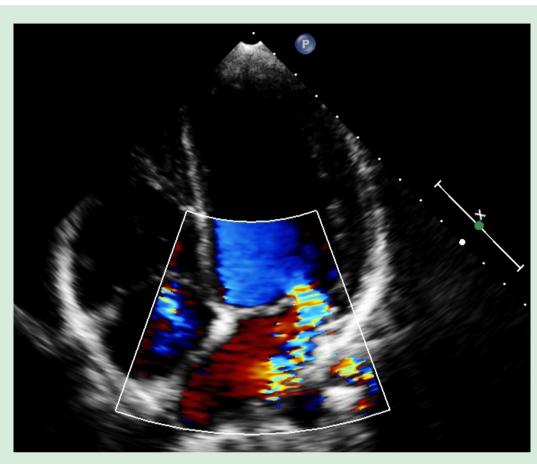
RM: mitral regurgitation, RT: Tricuspid regurgitation, VE: Left Ventricle, VD: Right Ventricle. 2D Echocardiography in apical 4-chamber view showing the eccentric jet of mitral regurgitation.
